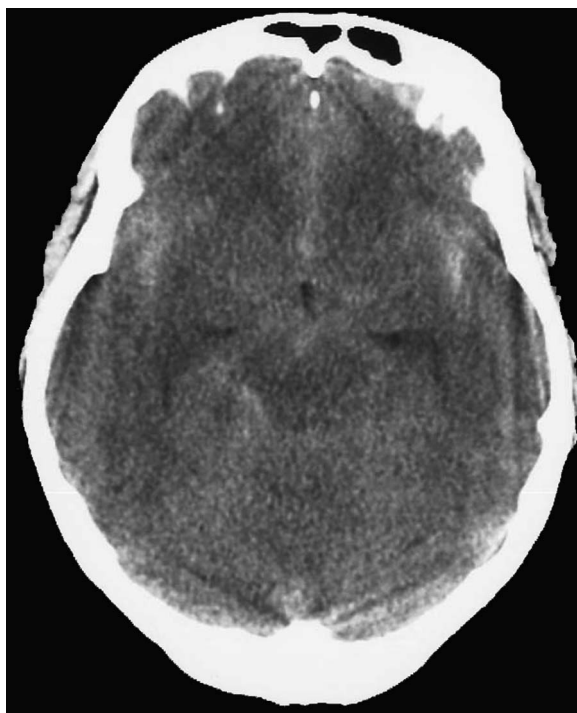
Initial CT scans shows thin subarachnoid hemorrhage in the basal cisterns and sylvian fissure.
